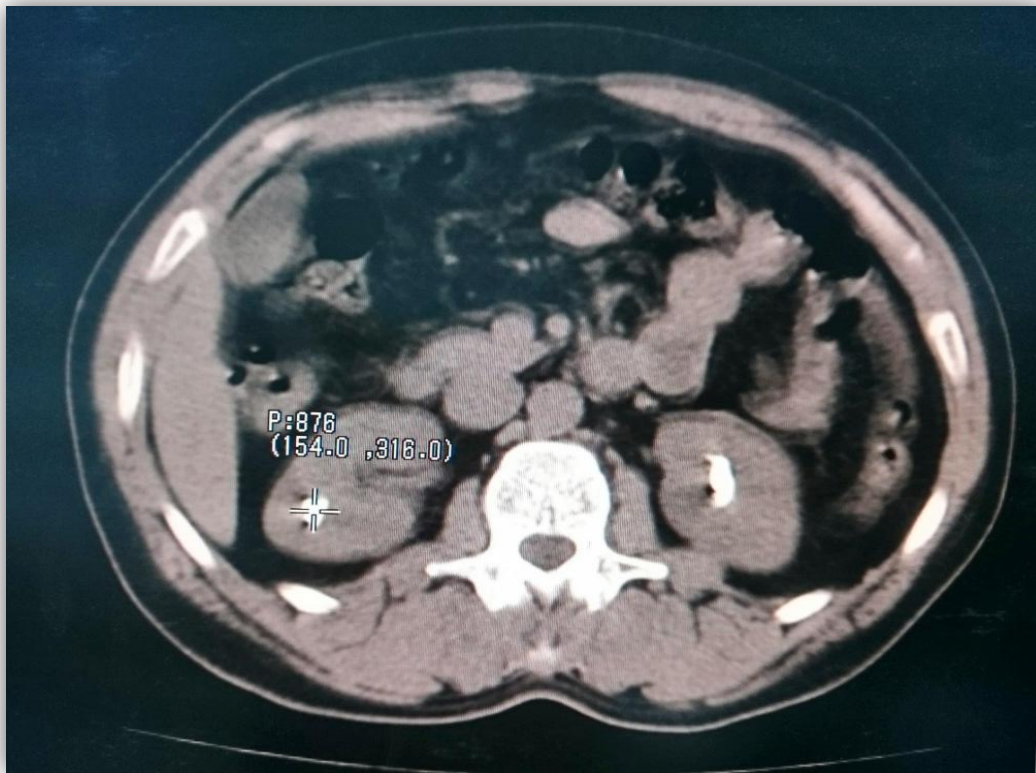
represent the CT –KUB to the patient with bilateral renal stone with CT- Number 876.
